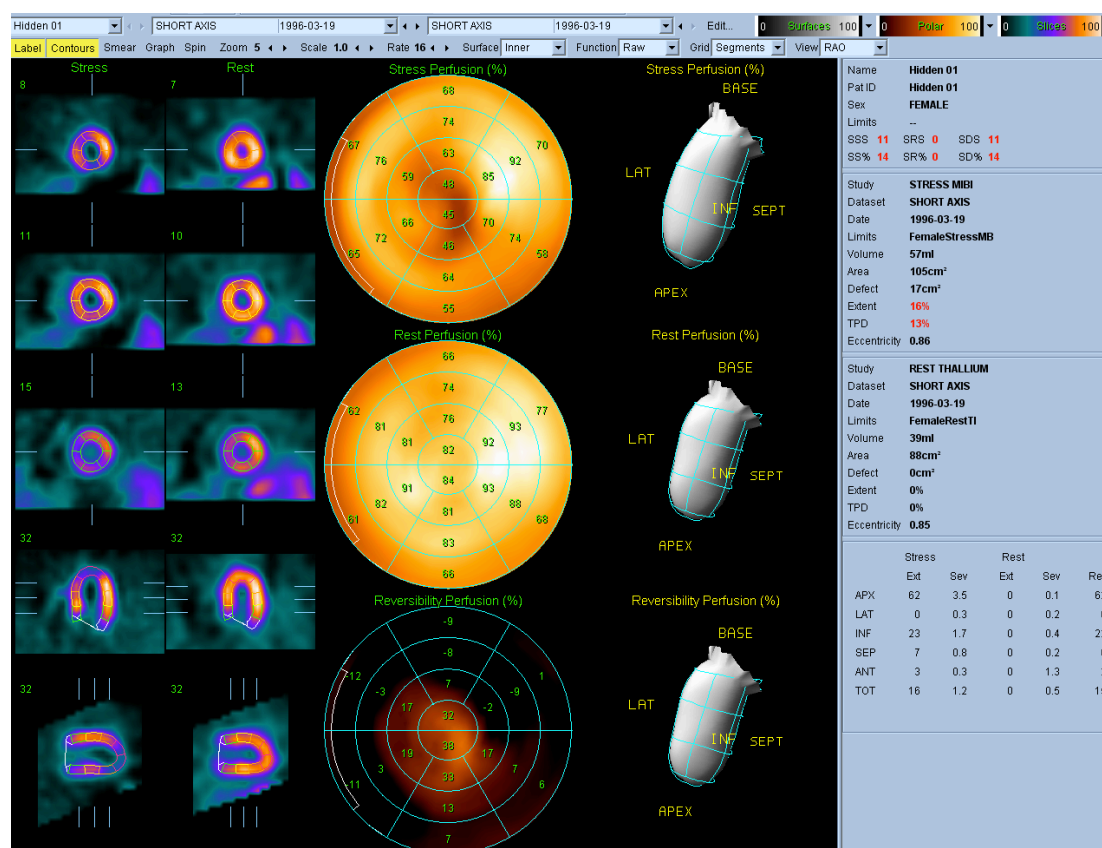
SPECT MPS. Adapted from <http://cedars-sinai.edu>. SPECT MPS showing semi-quantitative scores and an overall summary polar plot of homogeneity of tracer at stress, and demonstrating an apical perfusion deficit.
